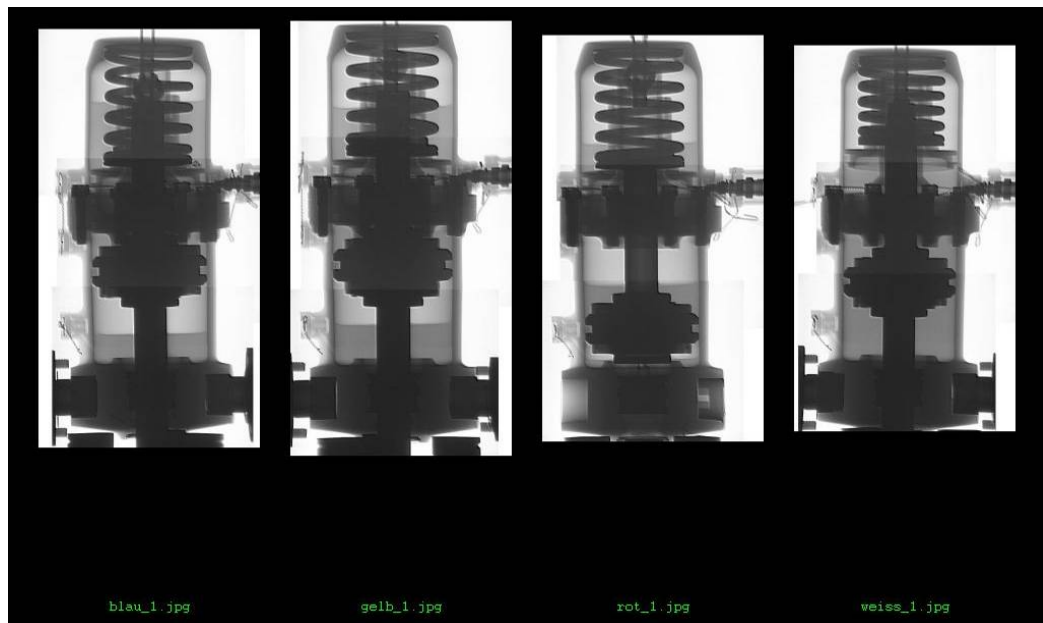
X-ray images, shock absorbers: Blue – Yellow – Red – White
